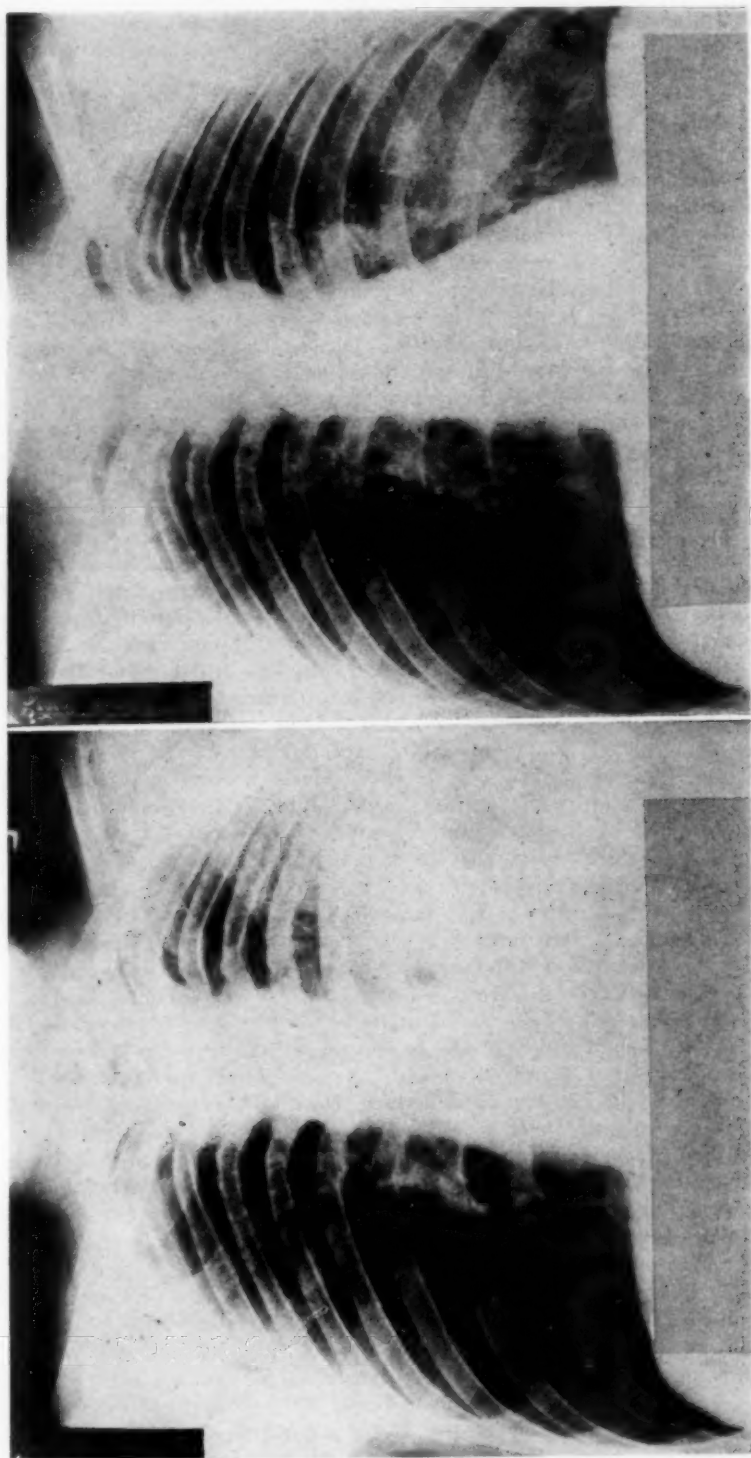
Roentgenograms of case 5 (left, March 31, 1943; right, July 17, 1943). Onset of empyema about January 25, 1943. Four thoracenteses were done between April 5, 1943 and April 23, 1943. The last roentgenogram showed a minimal amount of pleural thickening.
